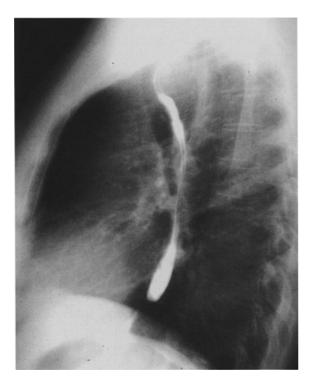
Vascular ring: radiography. Barium swallow esophagogram, showing the esophageal indentation due to the simultaneous presence of right aortic arch and anomalous left subclavian artery
